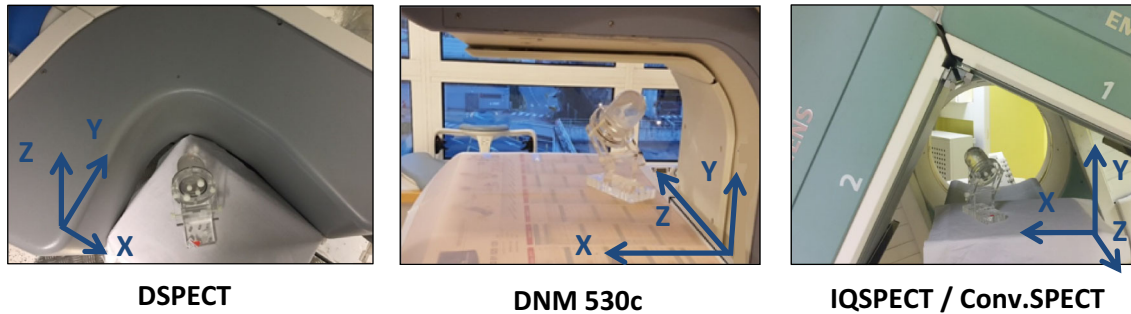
Representations of the three orthogonal axes (X, Y, and Z) and of the orientation and placement of the left ventricular insert at the center of the field of view at baseline, prior to any translation, for the DSPECT (left panel) and Discovery NM530c (middle panel) CZT-cameras and for the Symbia Anger-cameras (right panel, IQSPECT/Conv.SPECT).
